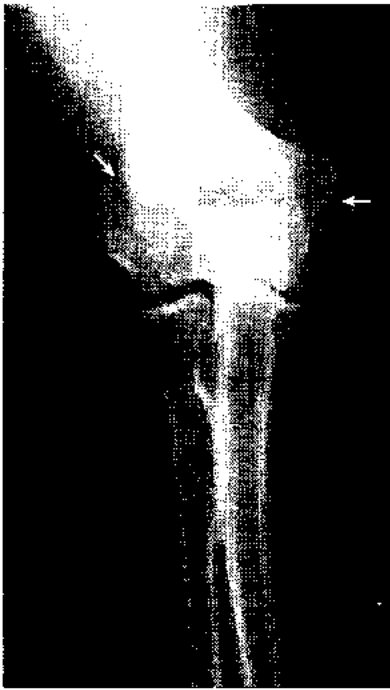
Anteroposterior radiograph of a transcondylar fracture with possible intraarticular extension into the lateral condyle (capitellum).
